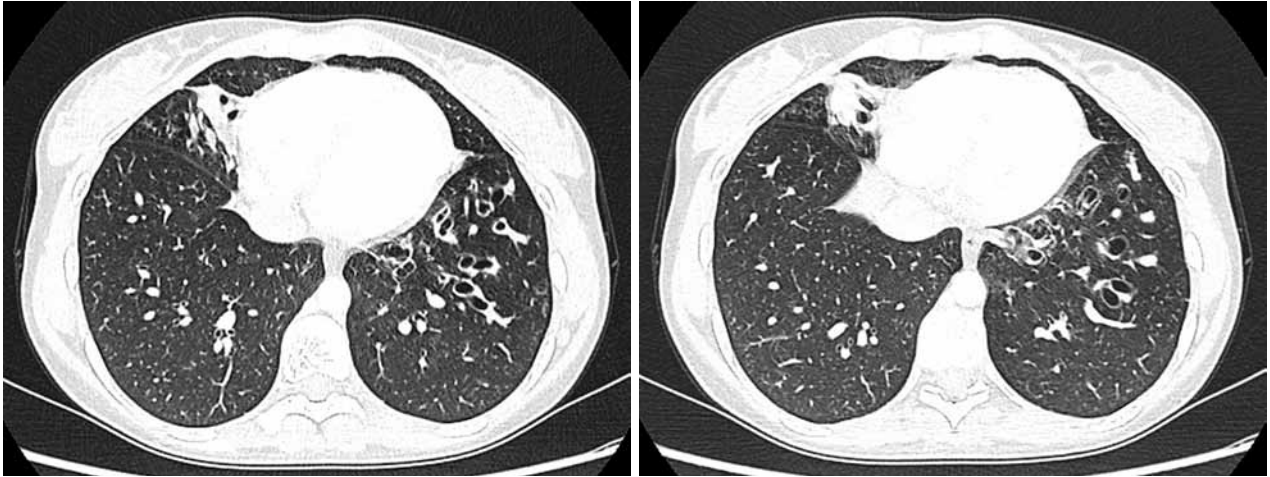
High resolution computed tomography image showing right middle lobe and left lower lobe bronchiectasis.
